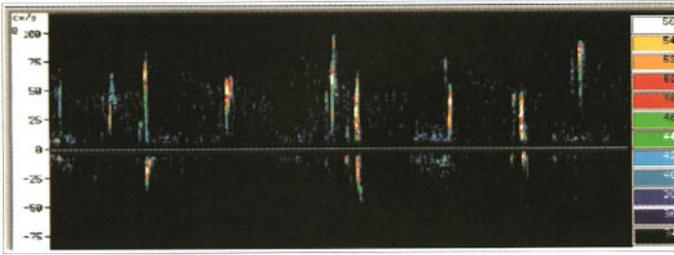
Microembolic signals. The consensus definition is provided in the text. A single-gate spectral transcranial Doppler recording of the middle cerebral artery flow shows multiple high-intensity transient and primarily unidirectional signals after intravenous injection of agitated saline in a patient with right-to-left cardiac shunt.
